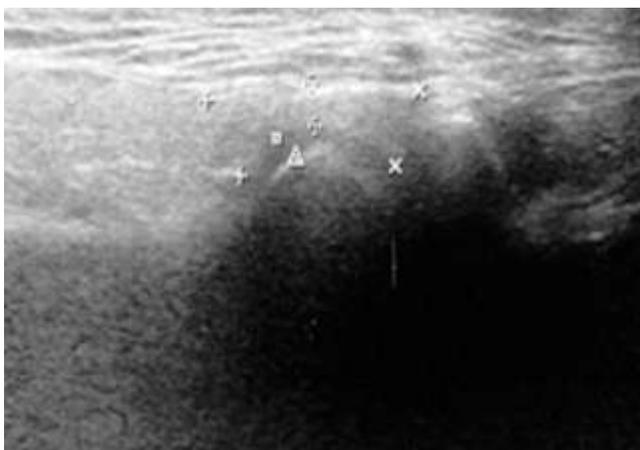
Ultrasound Image of the Articular Disc before Treatment with Distraction Splints; the Boundaries of the Disc are Indicated by Dots
